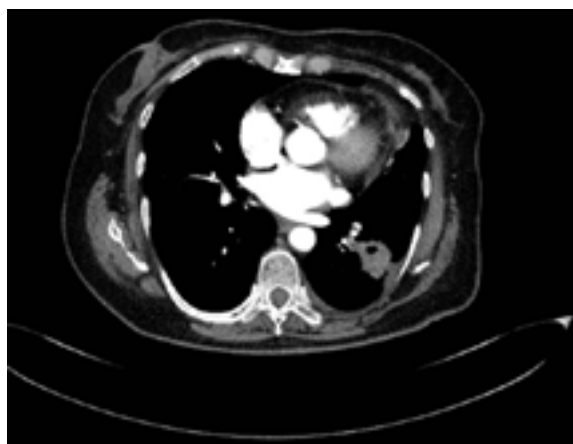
High resolution CT image showing nodule in lung parenchyma with spiculate margins and central necrosis.
